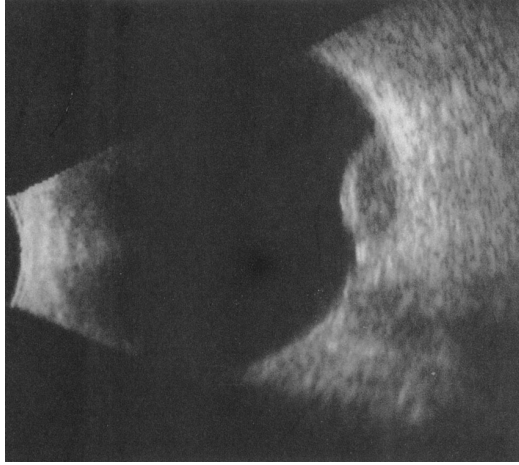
B-Scan ultrasonogram showing dome-shaped choroidal mass with acoustic hollowness, characteristic of choroidal melanoma ²⁵
